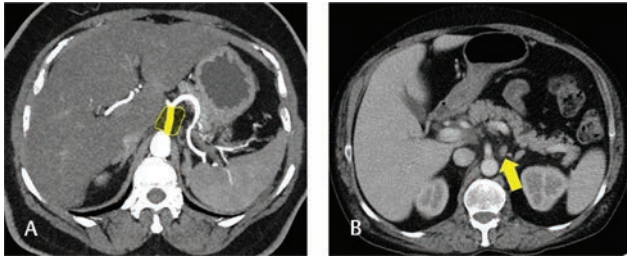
Station 9. Axial CT (A) in arterial phase shows the celiac trunk along which lie the station 9 (yellow area in A). Axial CT (B) in venous phase shows a small celiac node in a patient with known gastric carcinoma (arrow in B). CT, computed tomography.
